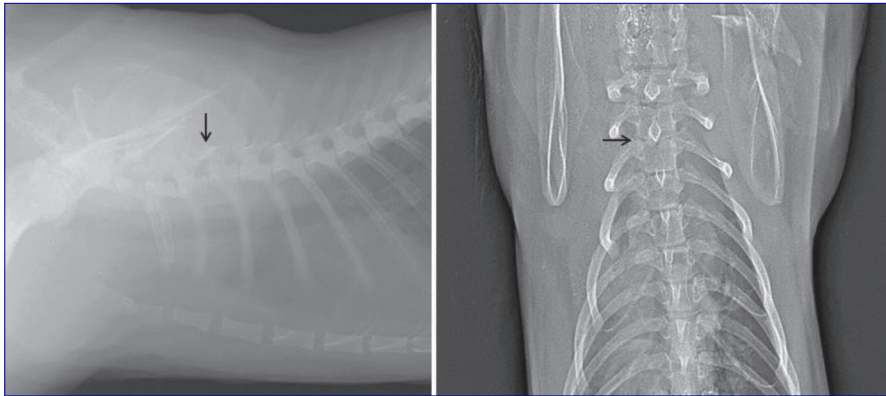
The views of dorsal dislocation of 3rd thoracic vertebra at the level of facet joints (arrows) in lateral and ventrodorsal radiographies
